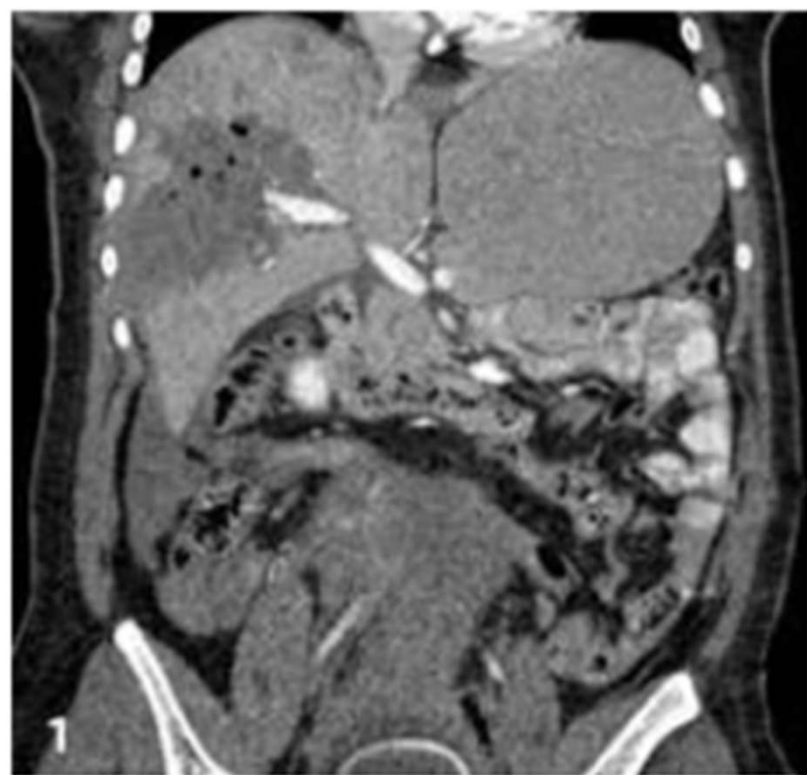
Coronal CT image of AAST grade 4 hepatic injury.
